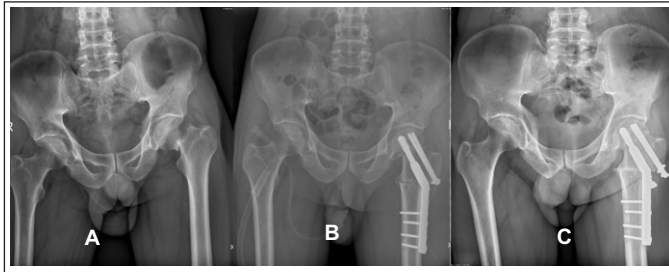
A. Showing X-ray of pelvis with left sided neck of femur fracture pauwels type 3 B. Immediate post op X-ray C. Follow up X-ray at 6 months showing complete bony healing at osteotomy and fracture site.
